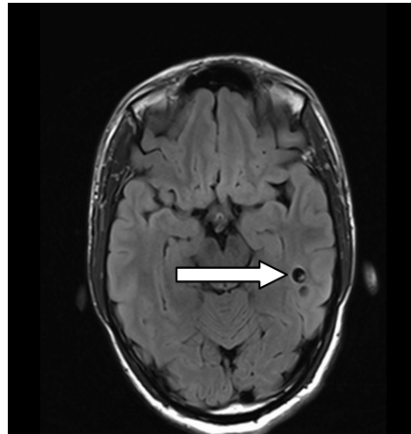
MRI-FLAIR axial non-contrast
